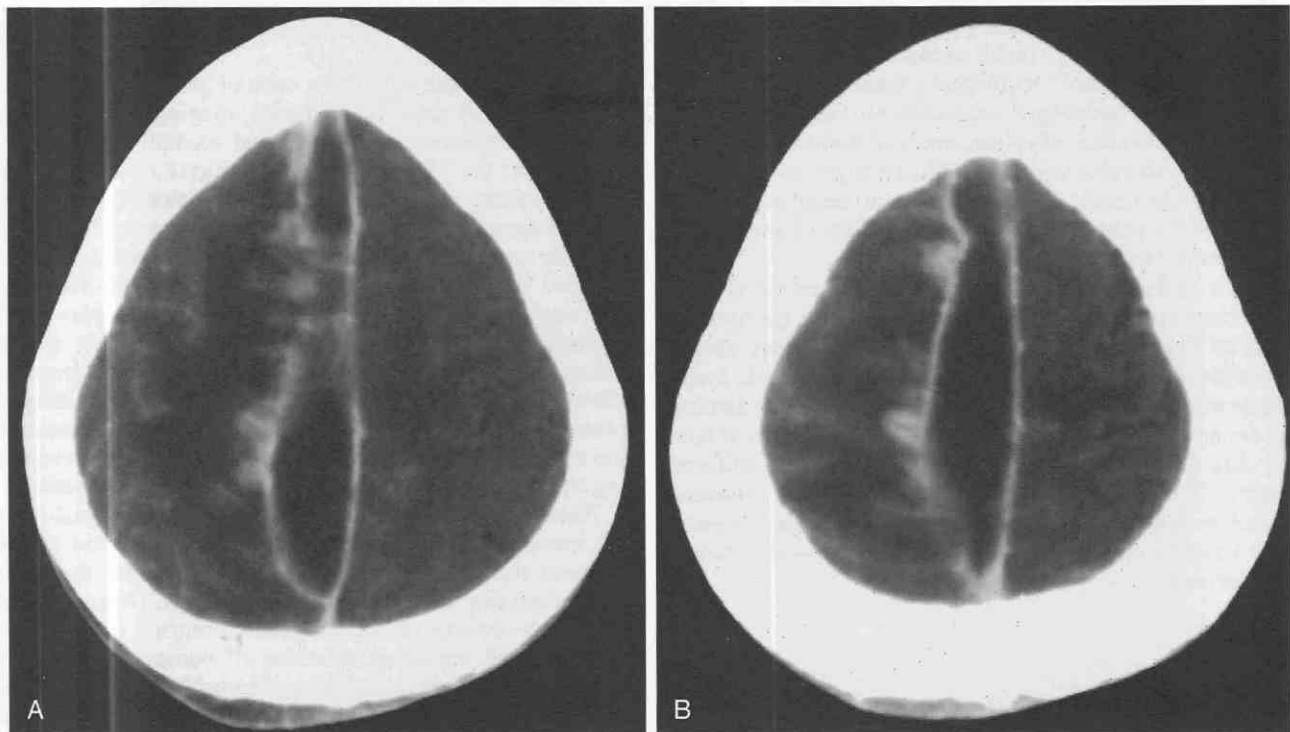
Subdural empyema. *A* and *B*, Enhanced axial CT images at the level of the falx cerebri show dural enhancement surrounding a subdural empyema.
